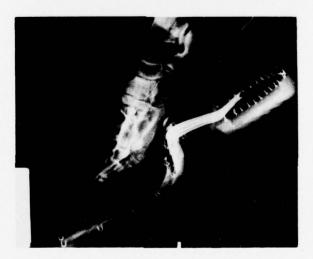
Roentgenogram of foot on a rudder pedal. (AFIP Neg. 73-4261-4.)
